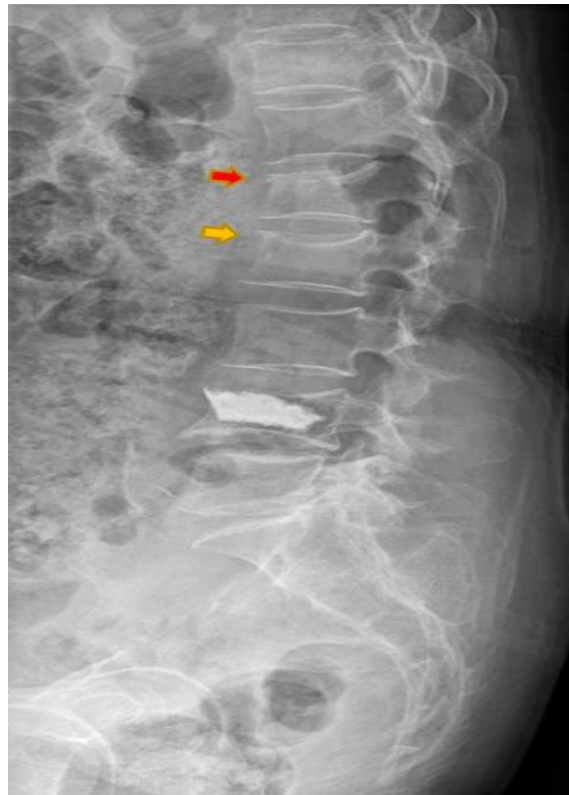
Lateral view of plain radiograph. The upper endplate of not only L1 (Red arrow) but also L2 vertebral body (Yellow arrow) was slightly lowered
